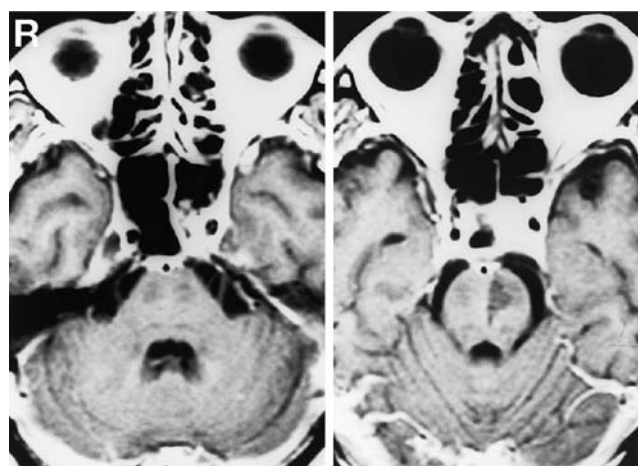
Axial T₁-weighted magnetic resonance images with gadolinium on day 5 showing (left) an enhanced mass attached to the clivus in the prepontine cistern and embedding the basilar artery, with partial opacification of the left sphenoid sinus, and (right) a hypointense area consistent with ischemic infarction in the left pons.
